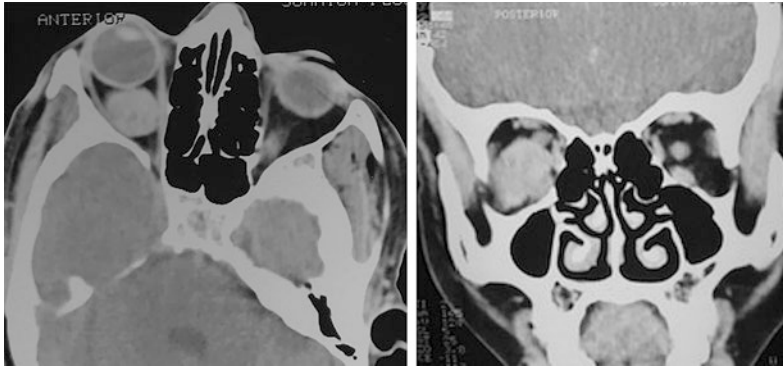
Cavernous hemangioma on CT scan in 42 years old female. a, b Axial and coronal reformatted contrast-enhanced CT images demonstrate a well-circumscribed intraconal enhancing lesion
